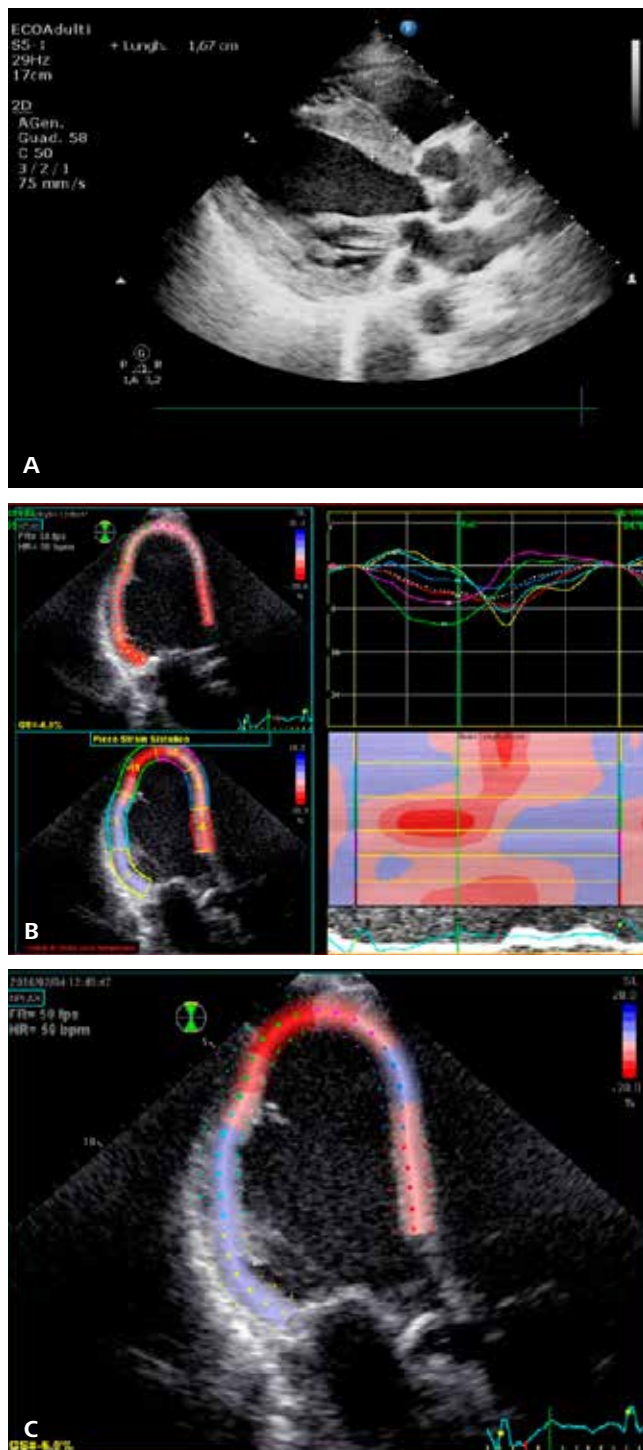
Transthoracic, speckle tracking echocardiography. A. Diffused thickening of the left ventricular walls. B. Dilatation of the left ventricle (left ventricular end-diastolic volume of 179 ml) and low ejection fraction of 32%. C. Hipo-akinesia of the inferior left ventricular wall
